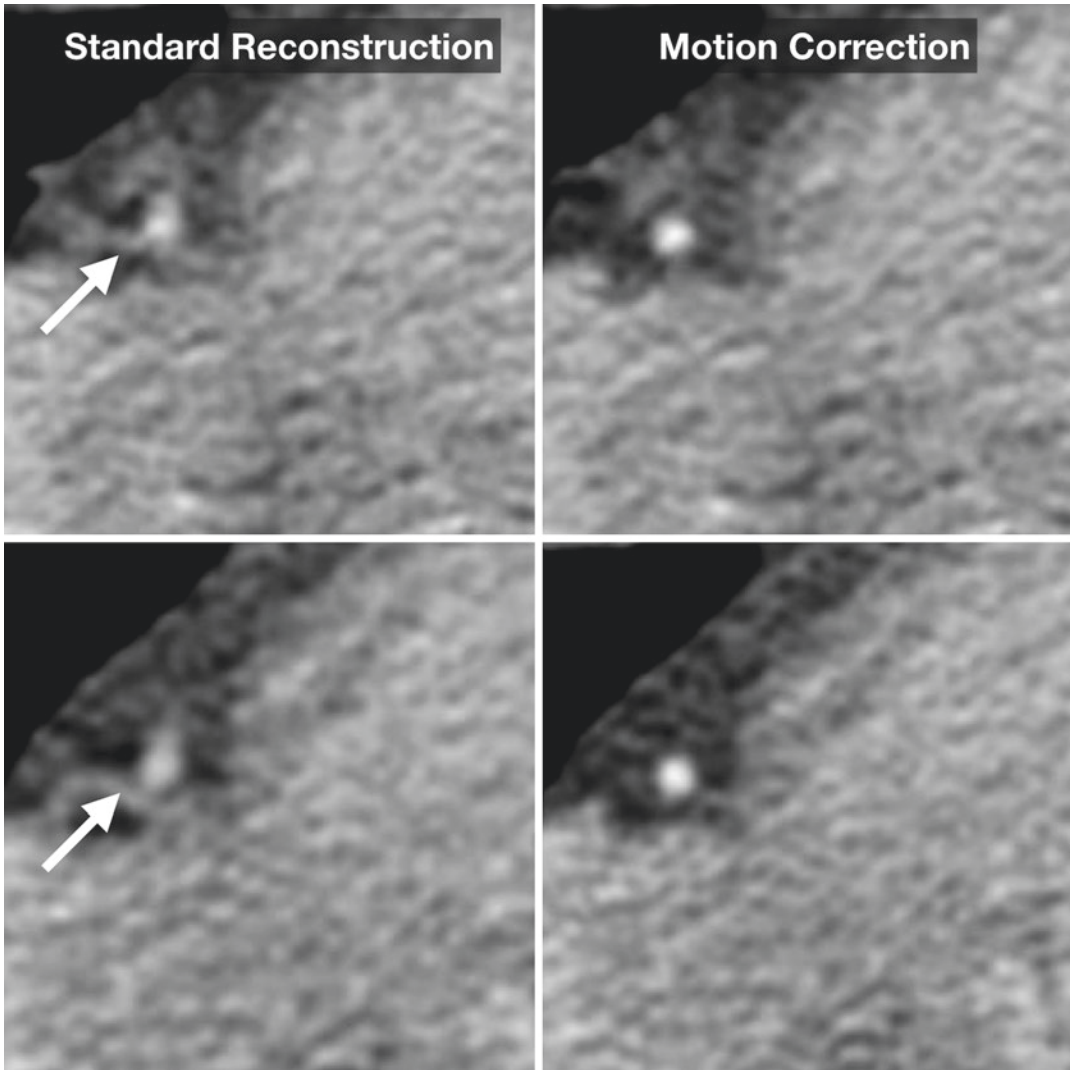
Prospectively triggered coronary CTA using standard iterative reconstruction without motion correction (left) demonstrates blurring of the right coronary
